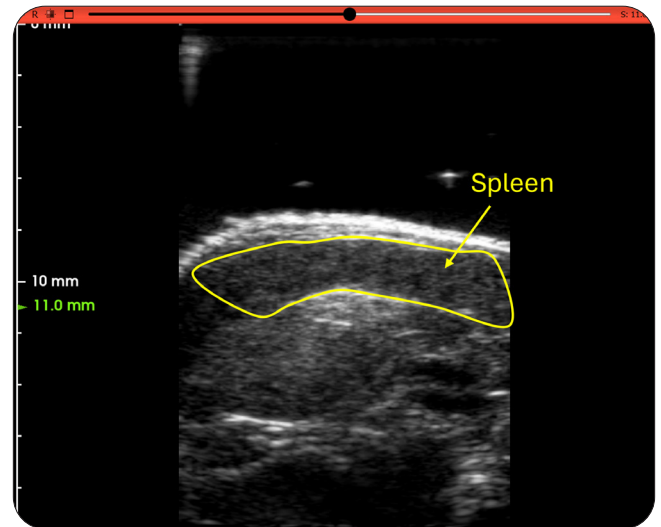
View of the spleen and surrounding features in the ultrasound livestream.
